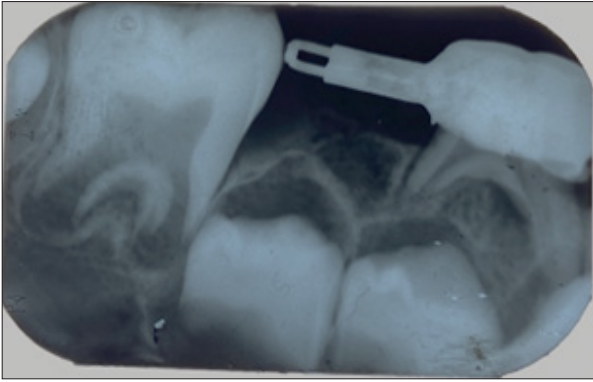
Radiograph showing distal shoe space maintainer converted into reverse band and loop space maintainer post eruption of 46- 24 month follow up.
